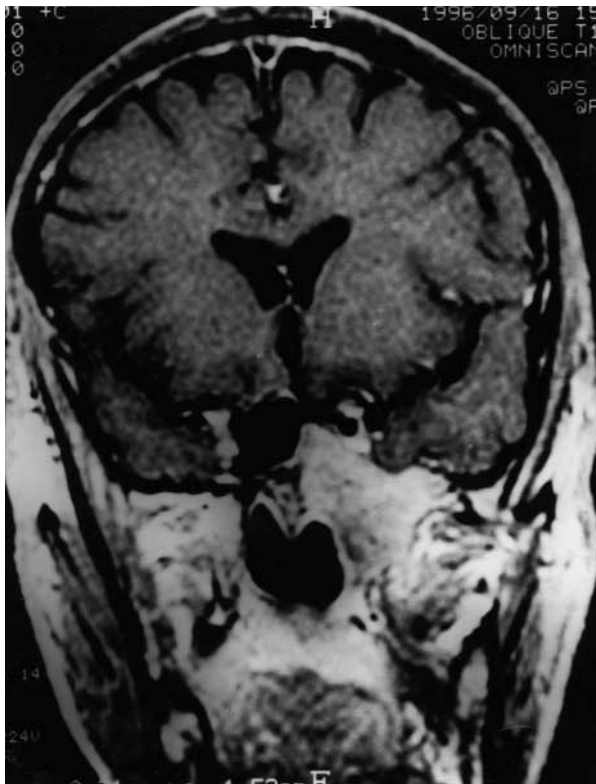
Coronal image on MRI scan showing superior, medial, lateral, and inferior extensions of the salivary gland choristoma.
